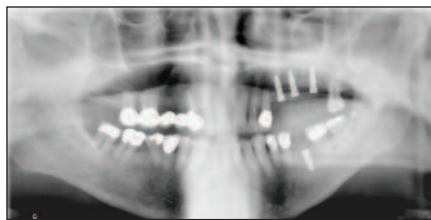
Case 1: Panoramic radiograph showing implant placement on maxillary left side.
